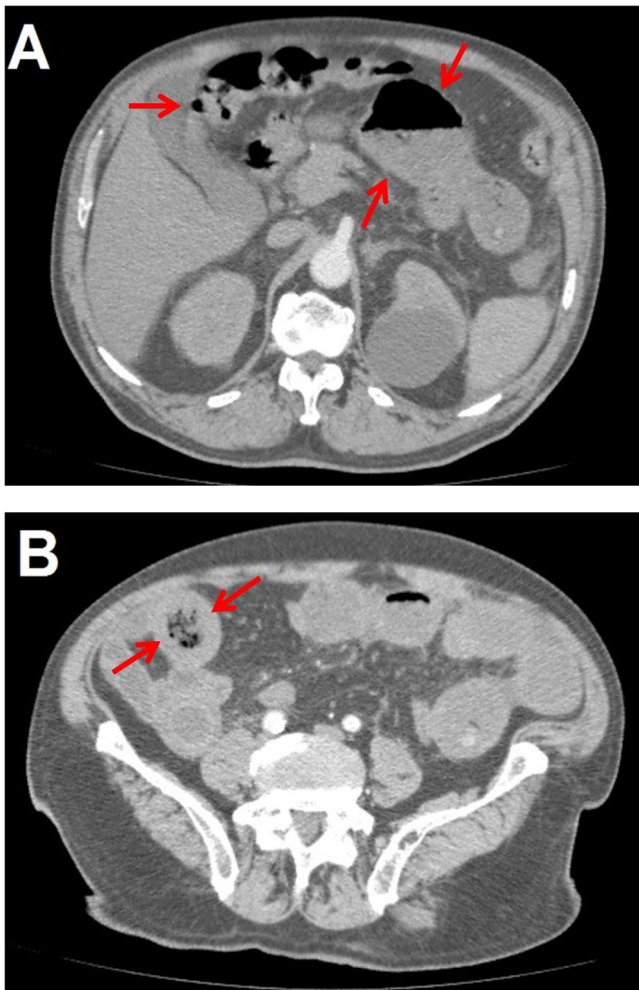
External CT showed:
